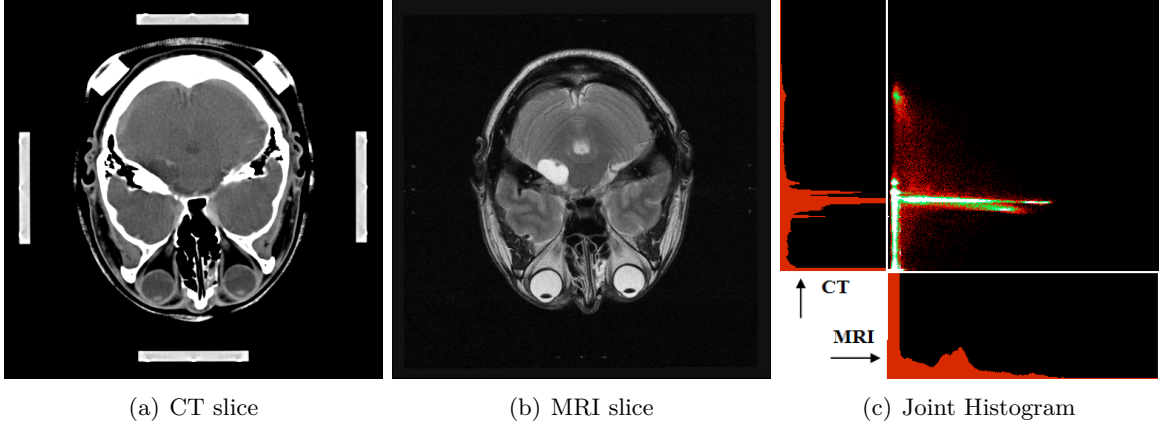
Registered head CT and MRI slices and their joint and individual histograms.
